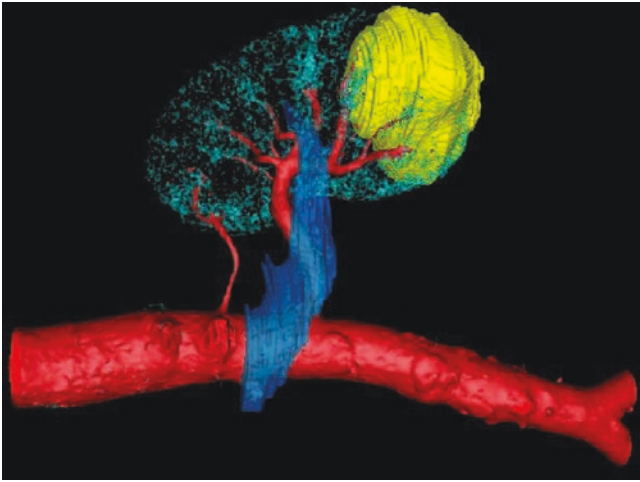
3D constructed CT images by OsiriX®
